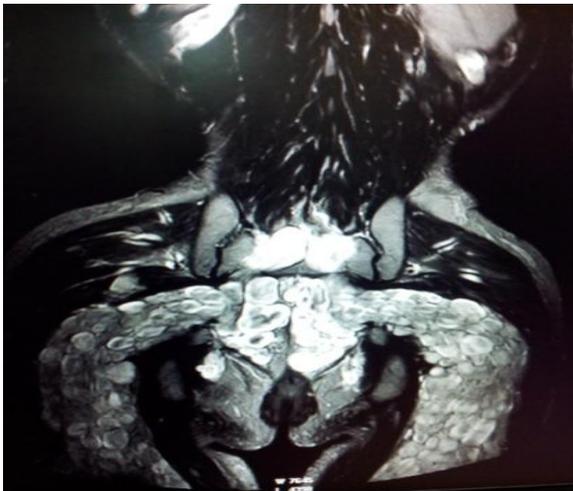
MRI of the pelvis showing extensive plexiform neurofibromas involving bilateral sciatic nerves on STIR coronal images
